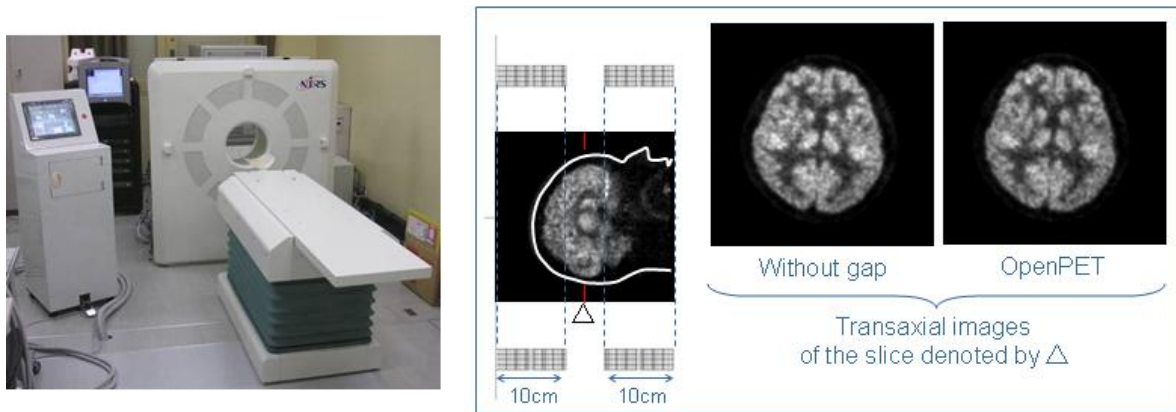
Experimental testing of the OpenPET geometry using FDG-PET data acquired with the jPET-D4 (left). The images obtained with and without the gap were very similar.
